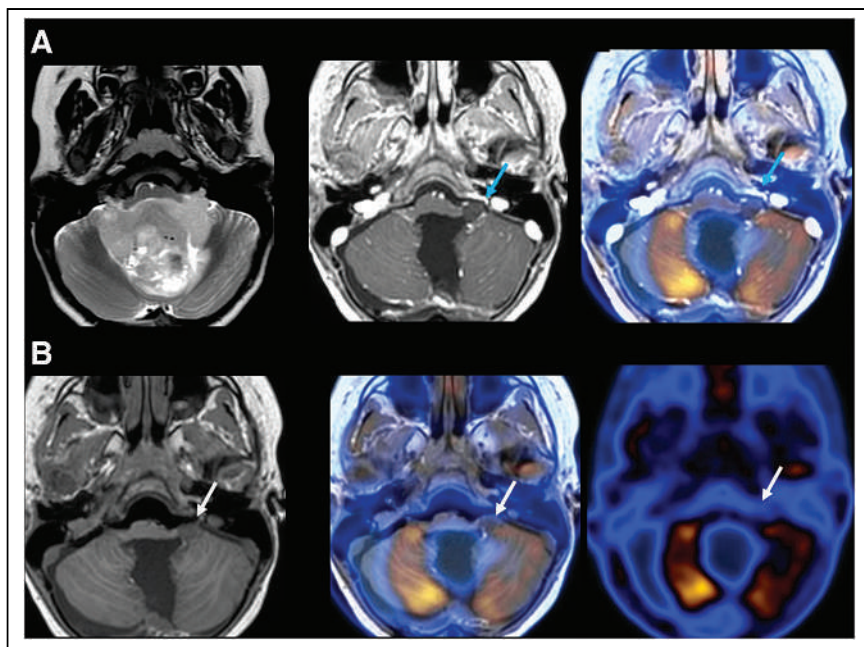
A 3-y-old girl after resection of posterior fossa tumor (anaplastic ependymoma: World Health Organization grade III). Three weeks after surgery, 8-mm left-sided nodule (blue arrows) in resection cavity showed no abnormal ^{18}F -DOPA uptake. Follow-up MRI on same day as ^{18}F -DOPA scan showed interval reduction in size and near-complete resolution of this nodule (white arrows), most consistent with initial postoperative changes. (A) From left to right: axial T2-weighted preoperative MR, axial immediately postoperative T1-weighted contrast-enhanced MR, and axial immediately postoperative ^{18}F -DOPA PET/MR images (B) From left to right: axial follow-up postoperative T1-weighted MR (3 wk), axial follow-up ^{18}F -DOPA PET/MR, and axial ^{18}F -DOPA PET images.
